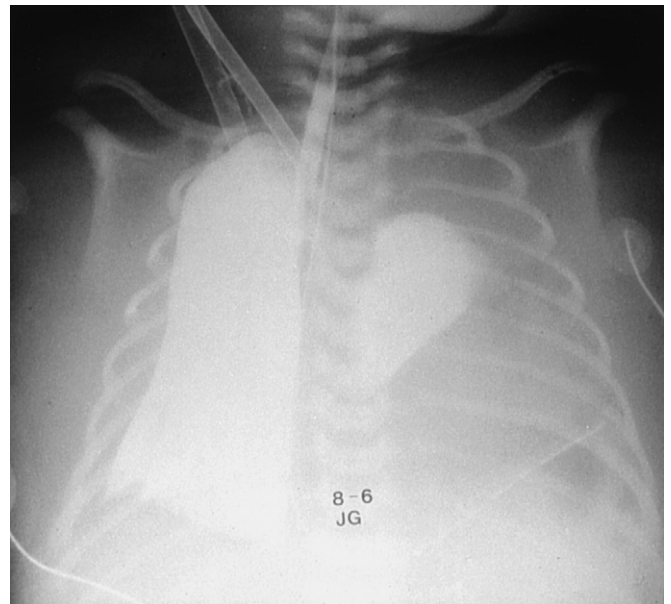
Chest radiograph of a left congenital diaphragmatic hernia being supported with extracorporeal membrane oxygenation. The lungs have been opacified with perflubron for liquid ventilation. The pulmonary hypoplasia can be appreciated. (Courtesy R. B. Hirschl, MD.)
